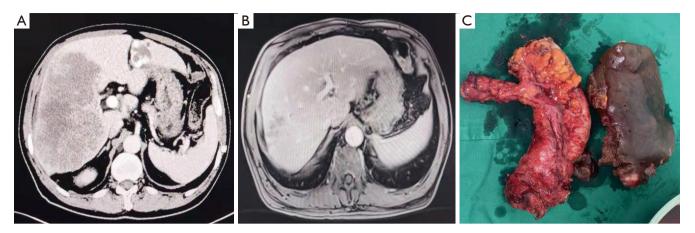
Cases of surgical resection of primary lesions and liver metastases after conversion therapy. (A) Abdominal CT of a patient whose CRLM was initially evaluated as potentially resectable; (B) abdominal CT of the patient at a follow-up visit after 8-cycle treatment with FOLFIRI + Cetuximab injections (biweekly); (C) primary lesions and liver metastases removed at the same resection. CT, computerized tomography; CRLM, Colorectal Cancer Liver Metastasis.
